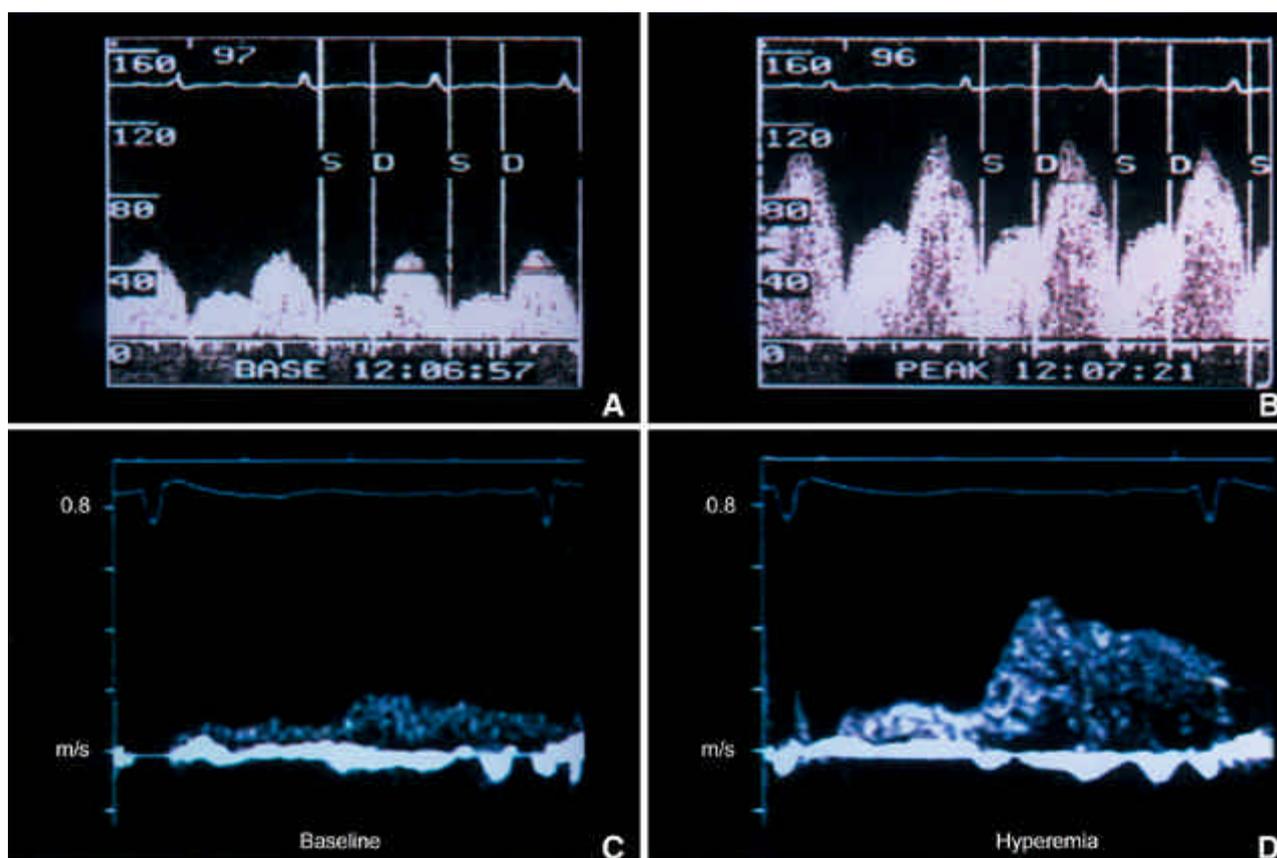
An example of baseline and hyperemic flow velocity obtained by intracoronary Doppler wire method (A, B) and transthoracic echocardiography (C, D).
